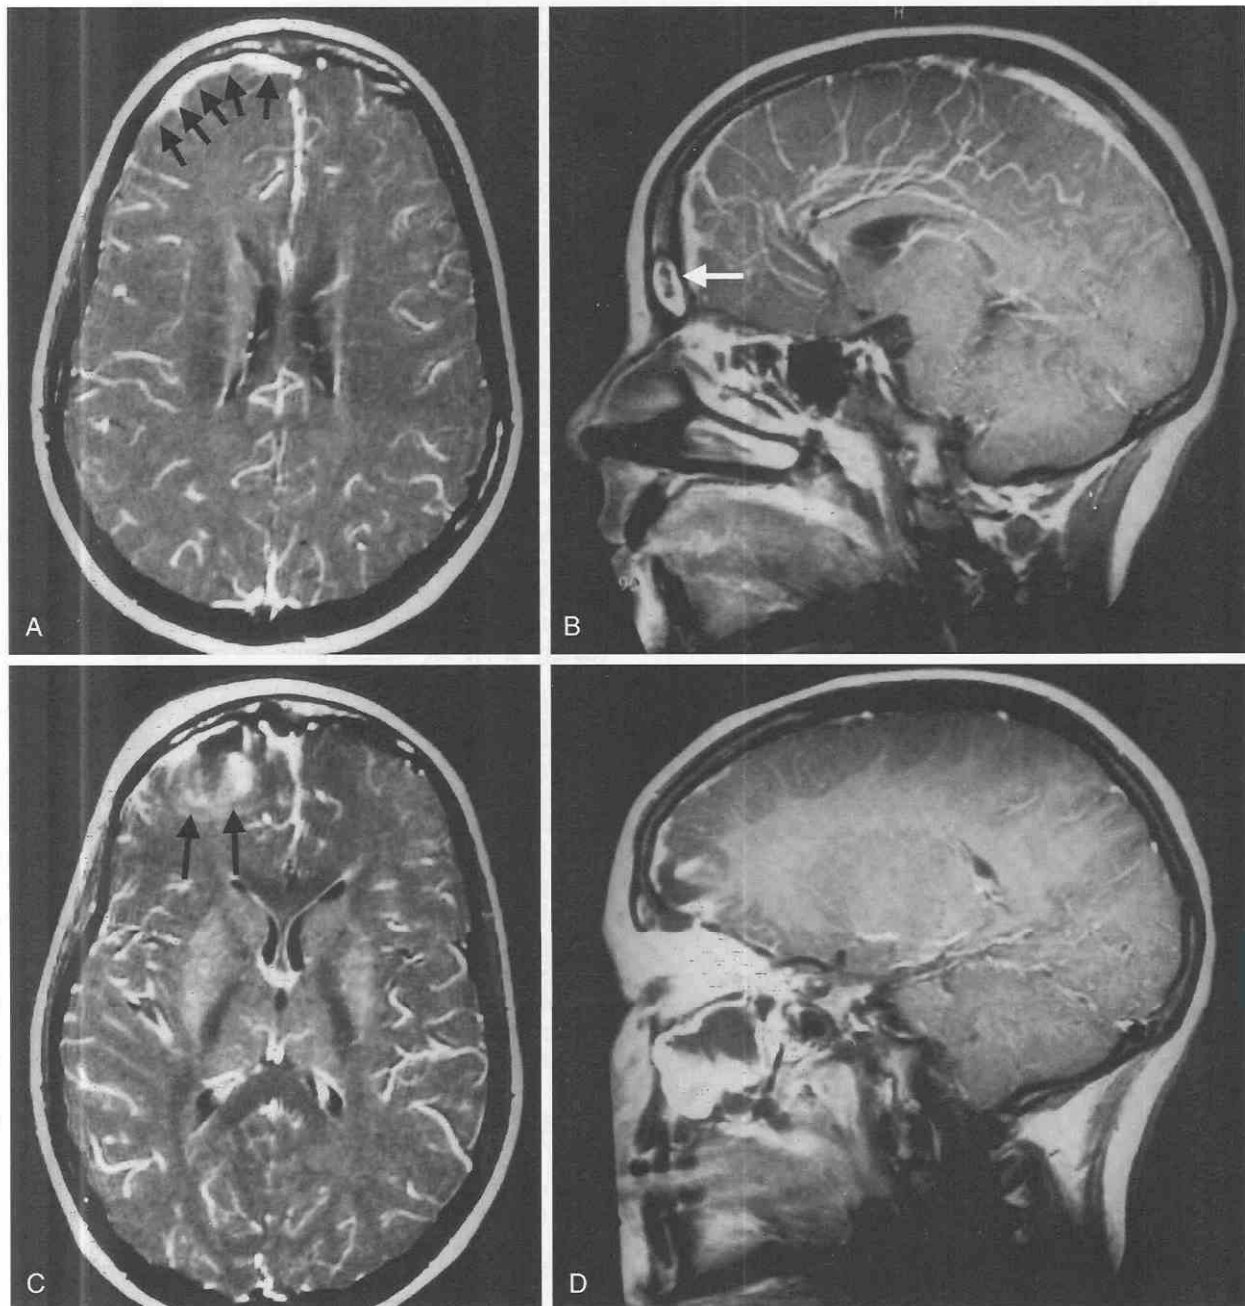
Sinusitis with intracranial extension. These contrast-enhanced T1-weighted images were obtained through the head of a patient with sinusitis and neurologic findings. A and B demonstrate meningeal enhancement (small arrows) in the left frontal region just posterior to the infected left frontal sinus (large arrow). C and D, Adjacent slices reveal the presence of an associated cerebral abscess (arrows) in the left frontal lobe. Cerebral abscess has occurred by direct extension, without apparent bone involvement, probably via emissary veins.
